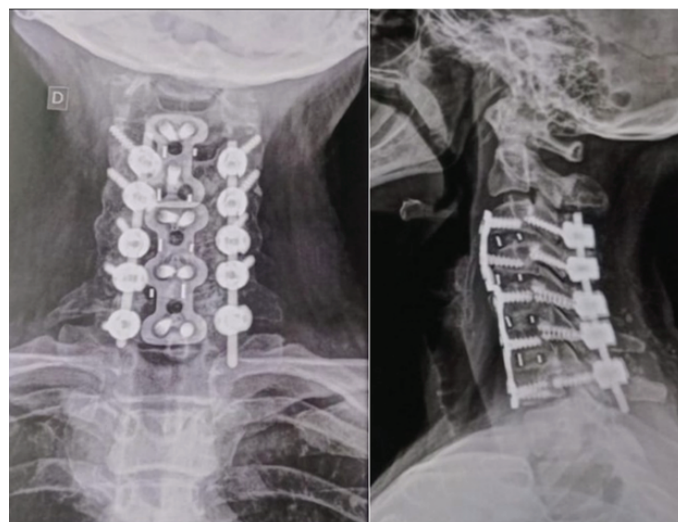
Cervical spine X-rays in anteroposterior (left) and lateral (right) views showing combined anterior and posterior instrumentation, characteristic of a 360-degree approach.
